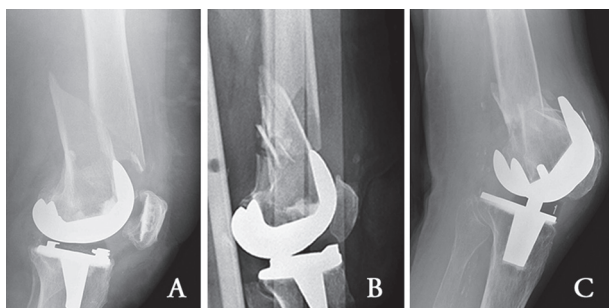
Radiographic lateral view of 3 different cases of Rorabeck type II distal femur periprosthetic knee fracture. These fractures can be differently classified according to Su et al. a) Su Type I: the fracture is located proximal to anterior femoral flange. b) Su Type II: the fracture extends cranially into the diaphysis starting from the anterior flange level. c) Su Type III: the fracture line begins at the level of the anterior flange and extends distally into the epiphysis
